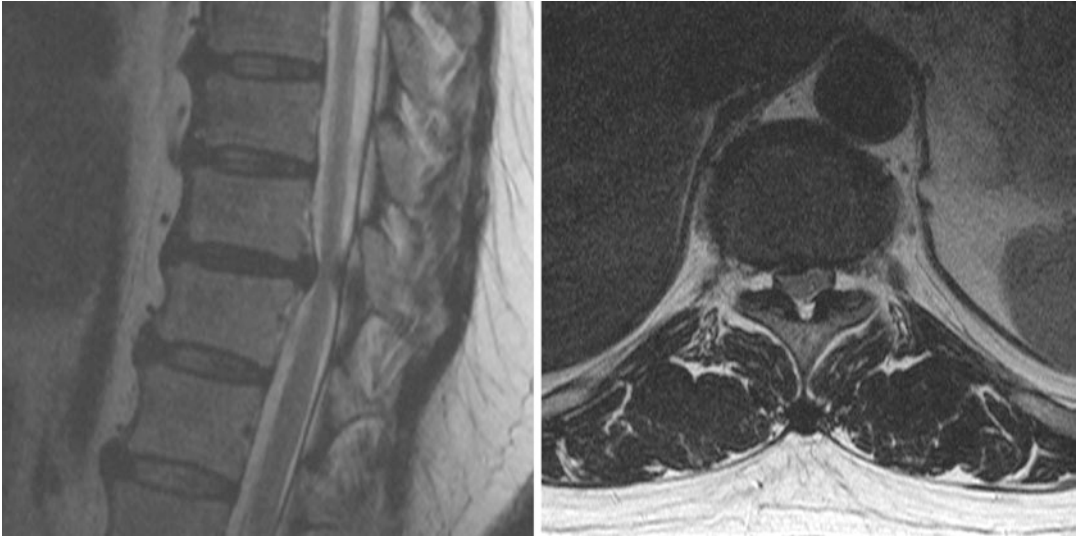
Preoperative MR images
